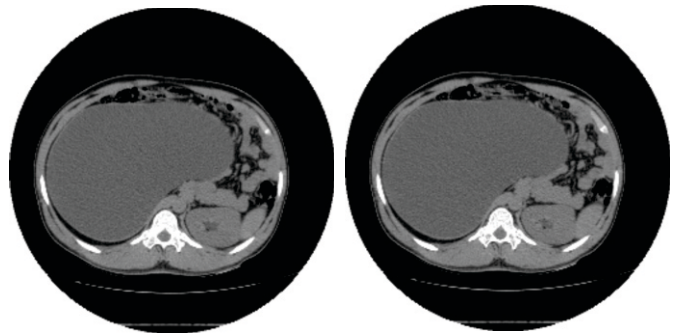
showing axial CT Abdomen with massively enlarged right kidney with normal left kidney.
